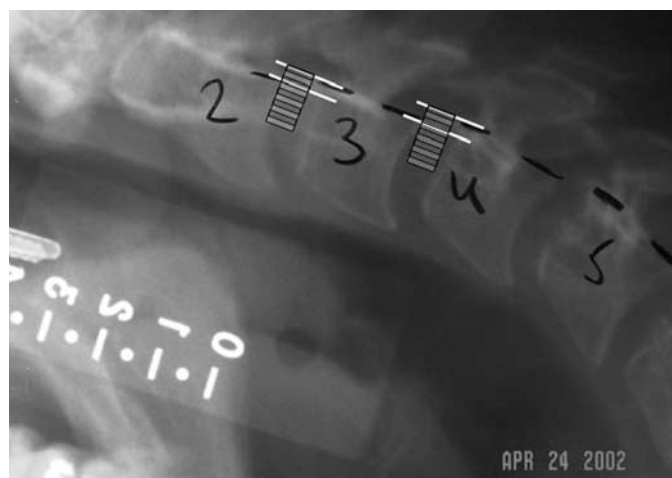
Cervical translation measured in mm (shown as vertical marks). Note the radiographic ruler in the field (lower left) which is used to benchmark the 1 cm distance at this magnification. There is 2-3 mm of anterolisthesis of C2 on C3 and 3-4 mm at C3 on C4.
